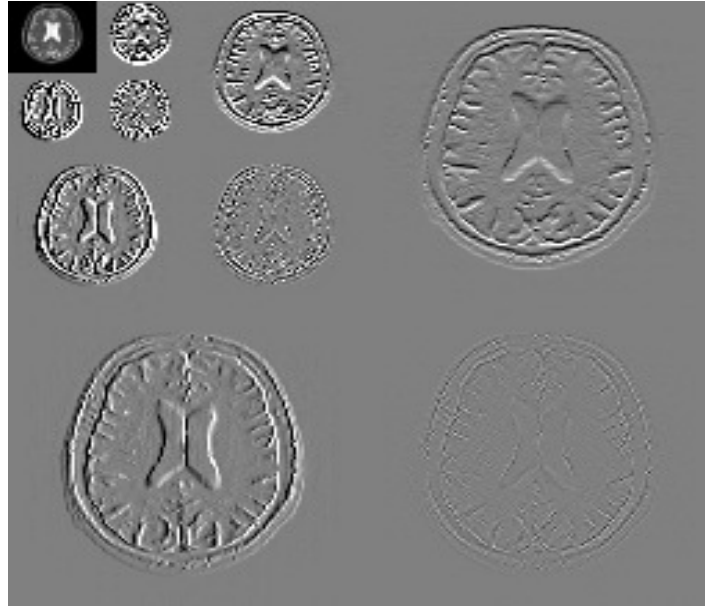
Discrete wavelet transform of one example MR image
